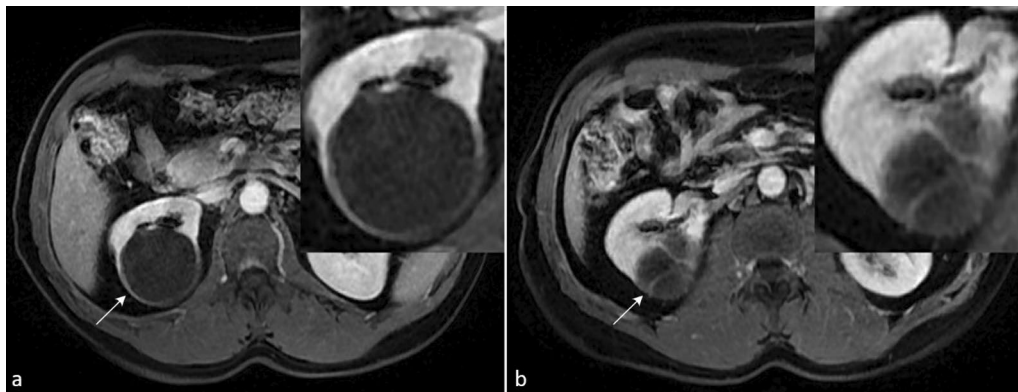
Right Bosniak IIF cystic renal mass (arrow) at the superior pole of the right kidney. a Axial T1-weighted sequence in portal venous phase showing minimally thickened wall (3 mm). b Axial T1-weighted sequence in portal venous phase shows two of the four thin enhancing septae
